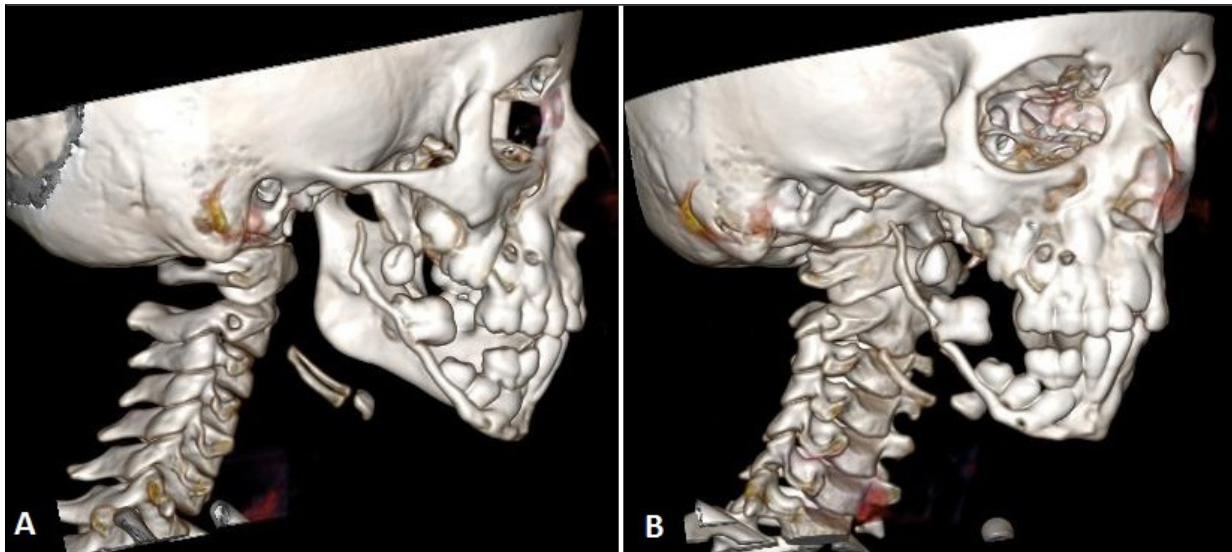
Follow-up CT scan images showing progressive bone destruction of the mandible and discontinuation of bone surrounding the mandibular canal.
